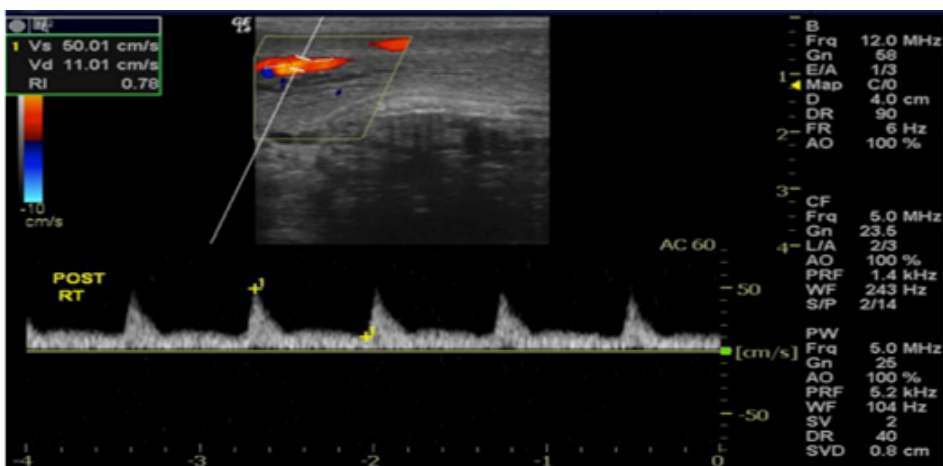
Doppler Ultrasound demonstrating Venous Leak leading to Erectile Dysfunction.
